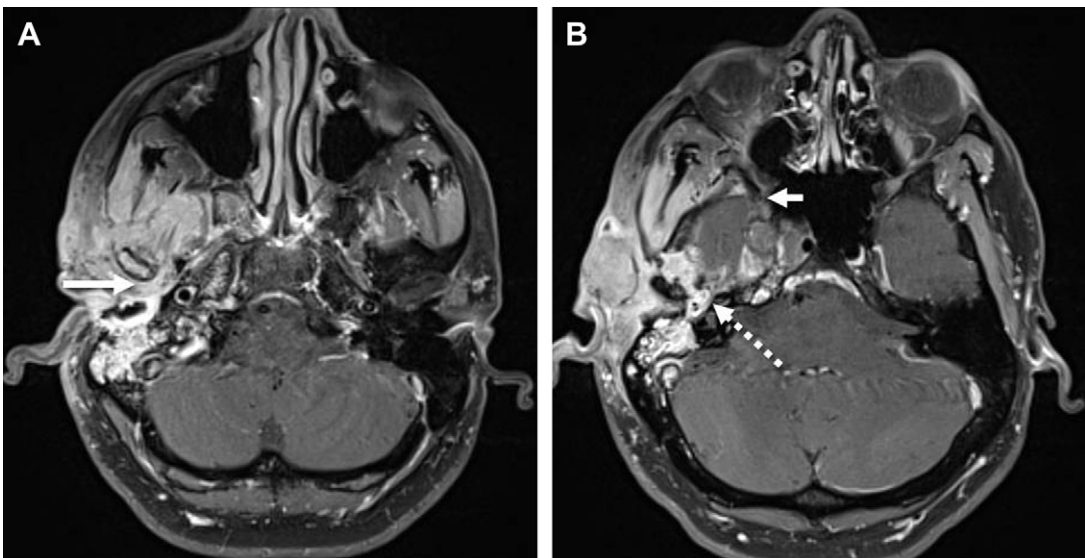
Auriculotemporal nerve involvement. Axial postcontrast fat-saturated T1-weighted images from a patient with a poorly defined carcinoma. Note abnormal enhancement in the region of the right auriculotemporal nerve (*long arrow*). Perineural tumor extension has occurred along the nerve to V2 and V3 segments of the right trigeminal nerve, with tumor in the right foramen rotundum (*short arrow*) and cavernous sinus, and tumor extension along the facial nerve (*dashed arrow*).
